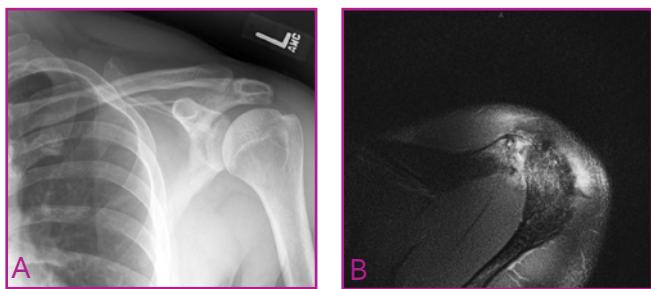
Imaging tests of a 22-year-old weight lifter, who presented to our clinic with worsening shoulder pain and limited shoulder activity at 1 year after initial injury. (A) Postoperative radiograph, showing anteroposterior view, with presence of osteopenia, subchondral lysis, and cysts at the acromioclavicular (AC) joint. (B) Postoperative magnetic resonance imaging, showing axial view, with osseous fragments, irregularity, and fluid noted in the AC joint.
